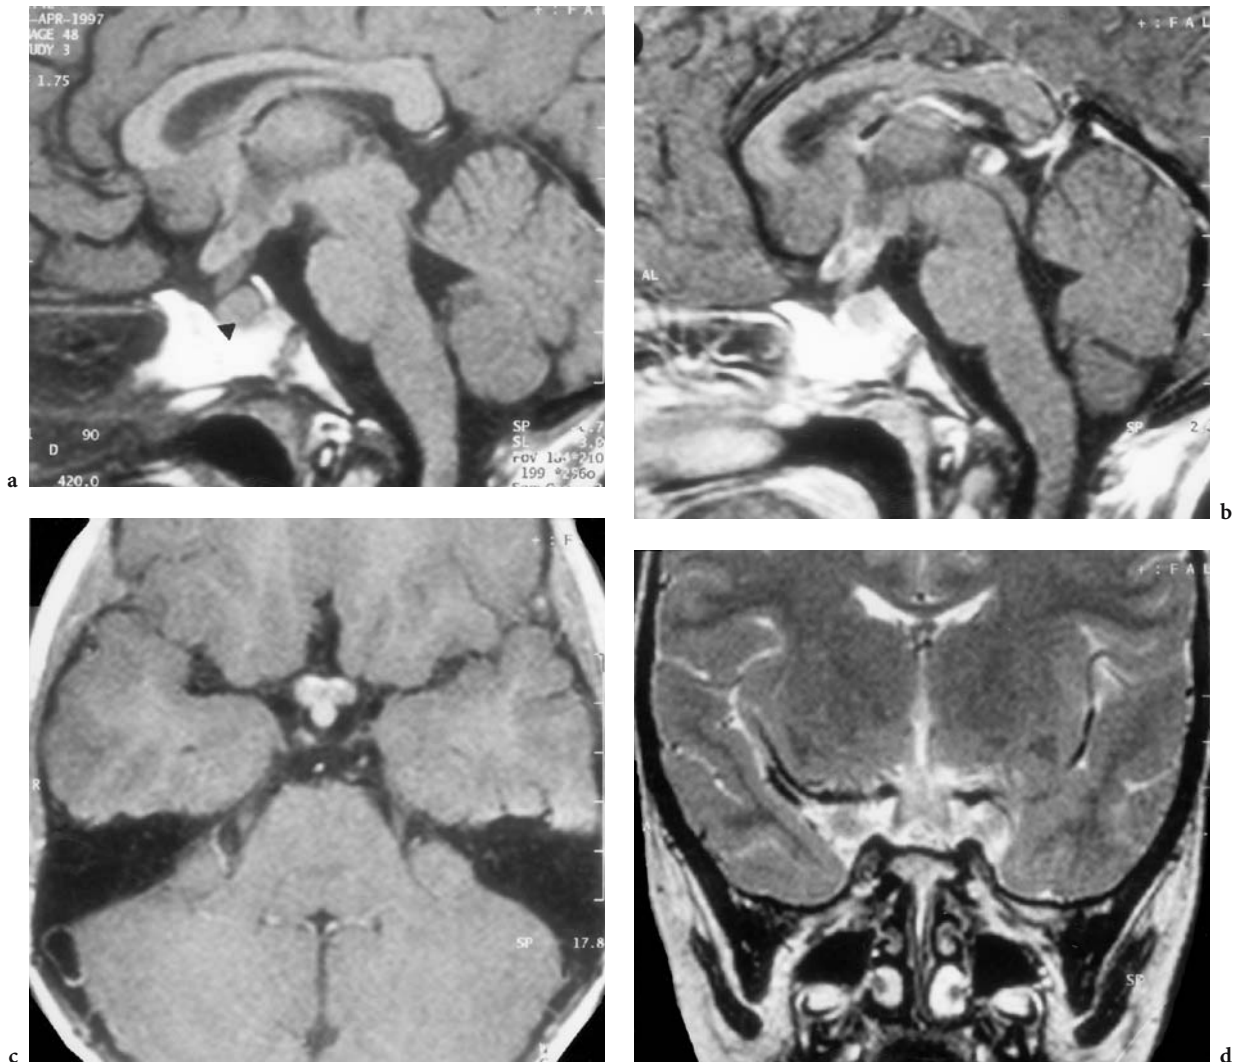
An 11-year-old girl with universal infantilism but no visual symptoms. Diagnosis: pituitary and hypothalamic germinoma. MRI: a Midsagittal T1-weighted view with enlargement of the optic chiasm and pituitary stalk. Note the round configuration of the pituitary gland and slight hypointensity of the posterior part (*arrowhead*). b Corresponding contrast-enhanced view with inhomogeneous signal enhancement of the chiasm, hypothalamus, and pituitary gland, the intraglandular tumor being unenhanced, corresponding to the primarily hypointense region in a. c Axial, T1-weighted, contrast-enhanced view with tumor enhancement of the chiasm and thickened pituitary stalk. d Coronal T2-weighted view demonstrating infiltration of the chiasm
